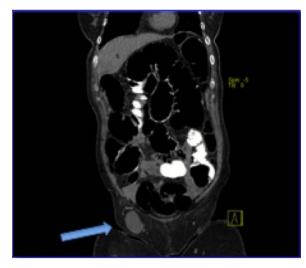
CT scan showing femoral hernia.
